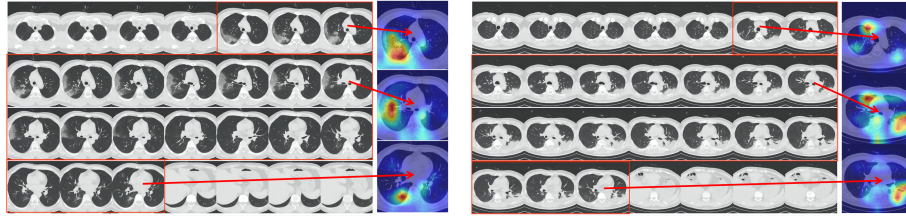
Visualization of patients with pneumonia by different etiologies on CT images. The difference in CT appearance between viral and bacterial pneumonia is shown from left to right.
